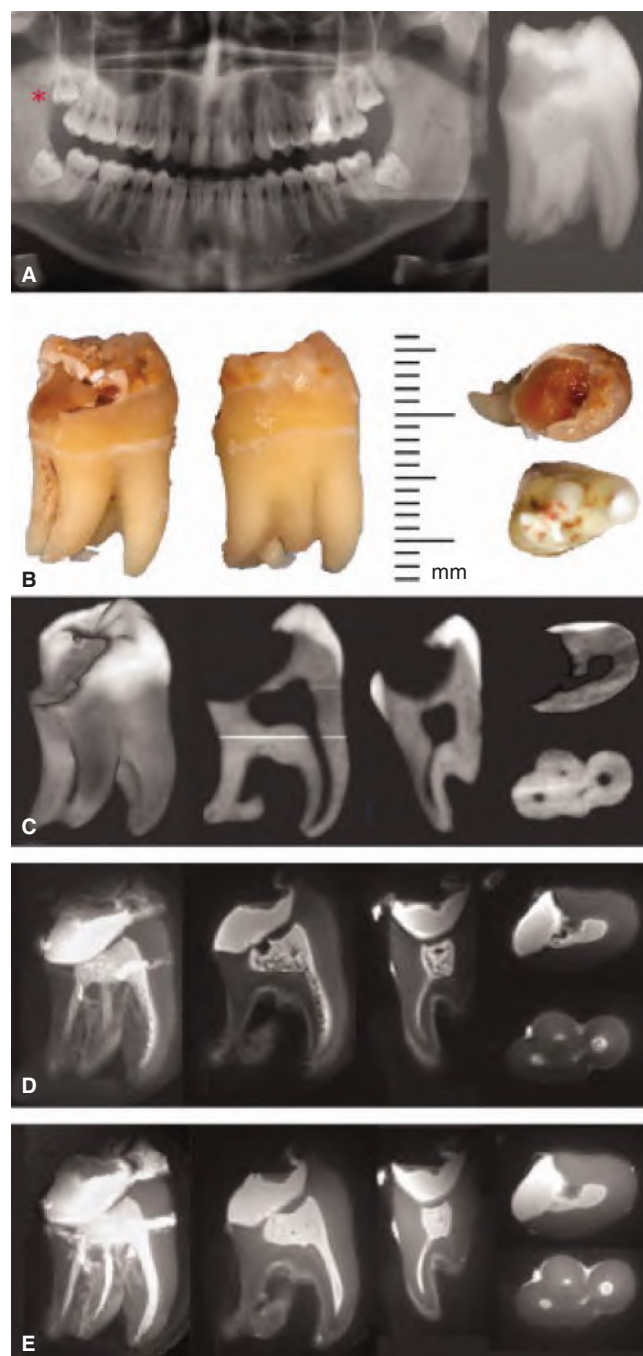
2 Comparison of imaging modalities. MR images were obtained by using 7T and 9.4 T devices. A. *In vivo* and *ex vivo* radiographs; B. photography; C. 3D cone-beam computed tomography (CBCT); D. 3D UTE MRI; E. 3D ZTE MRI of carious molar. (Adapted from Hövener JB, Zwick S, Leupold J, et al. Dental MRI: imaging of soft and solid components without ionizing radiation. *J Magn Reson Imaging* 2012;36: 841-846. Used with permission.)
